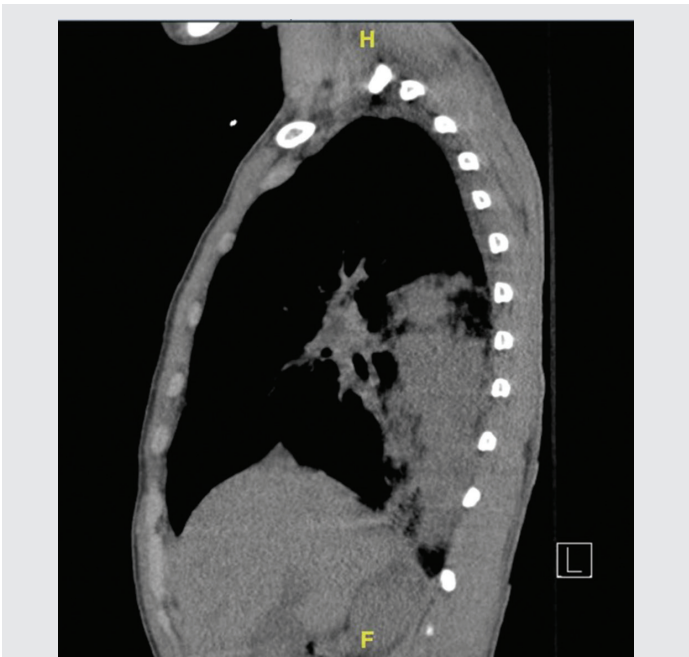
Computed tomography scan of the chest (sagittal plane) reveals a RLL infiltrate.
